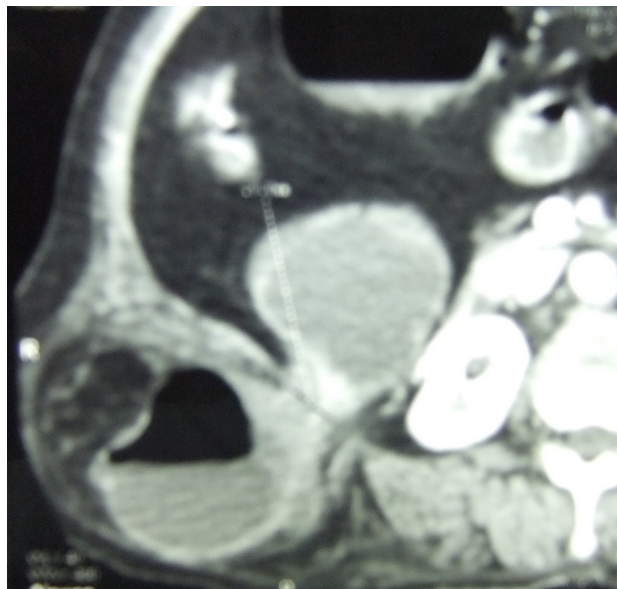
Transversal section CT of right Grynfeltt hernia.
